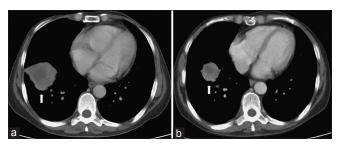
(a) Chest computed tomography in January 2018, before treatment, showed a tumor in the right lower lung of about 5.8 cm (arrow). (b) Chest computed tomography in May 2018, after three courses of chemotherapy, showed a great decrease in the size of the tumor (arrow)
